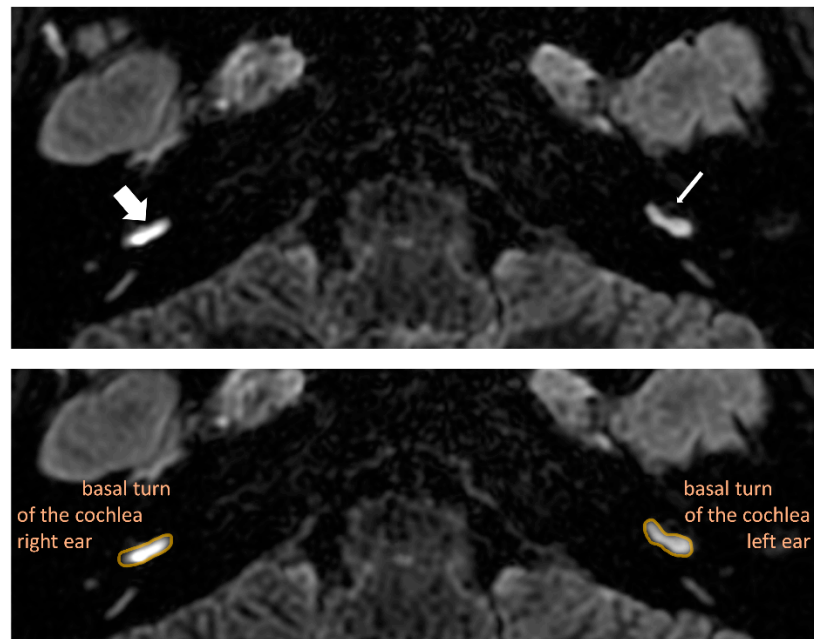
Delayed post-contrast 3D-FLAIR axial image of both ears at the level of the basal turn of the cochlea. In the top image, there is more robust enhancement of the basal cochlear turn on the affected right side (thick arrow), compared with normal perilymphatic enhancement on the left side (thin arrow). The bottom image is the same as the top one but in the form of a companion scan with some line art applied to define specific anatomical structures for easier identification of observed pathologies.
